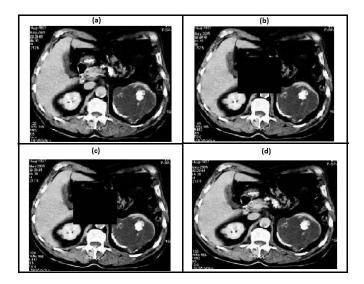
(a) The original host CT scan image, (b)Roi removed image,(c)Emebedded image without ROI, (d)Final embedded image with ROI
